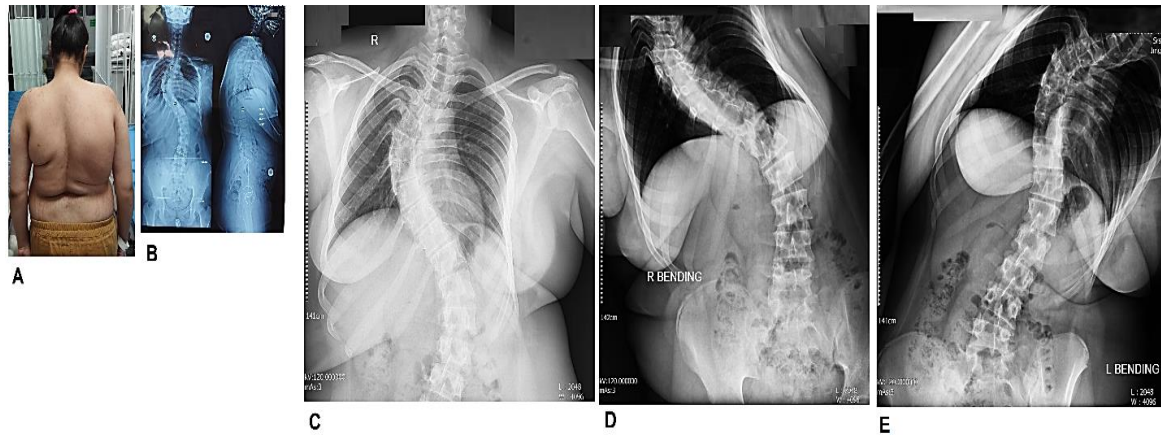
A to E) Preoperative photography and radiographies of the patient
